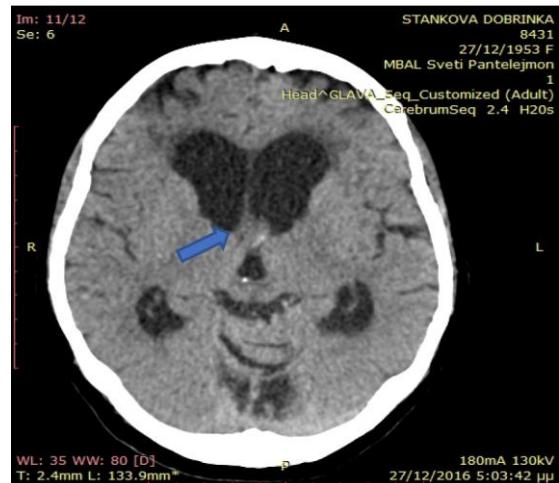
Axial CT scan demonstrating an ovoid third ventricular lesion (arrow).
